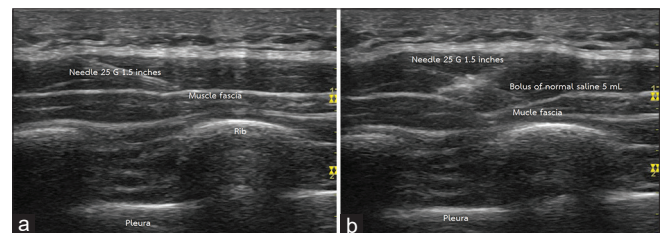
Sonographic imaging during intervention with in-plane technique. (a) Demonstrating needle tip touch the affected muscle fascia. (b) Demonstrating the bolus of normal saline 5 mL spread over the muscle fascia causing local pressure at this fascia
